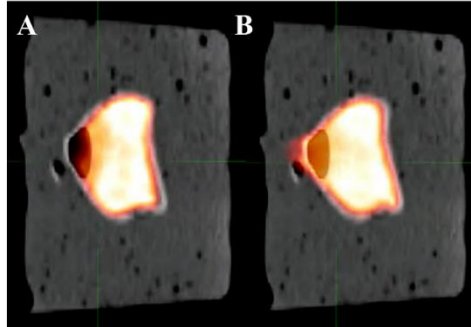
Static PET/4DCT images (PET/CT propagated to 4DCT MIP) of an irregular lesion fused using A) rigid image registration and B) deformable image registration
